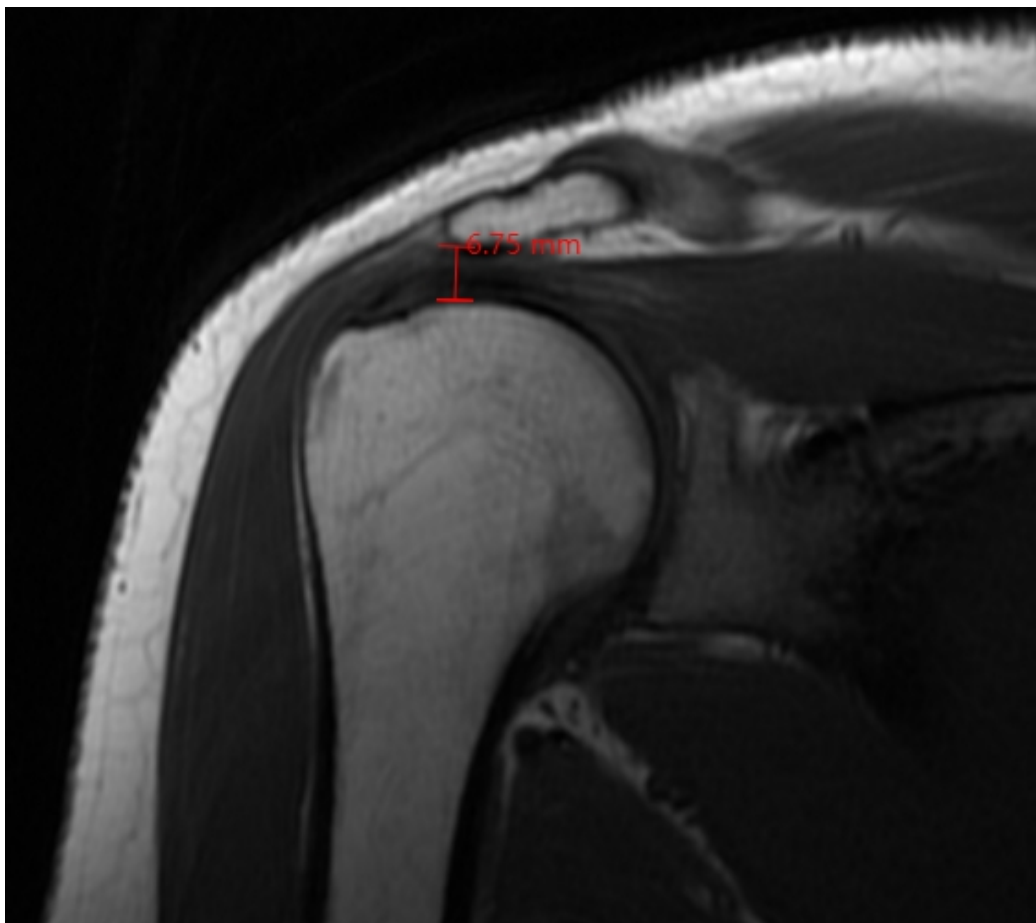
Measurement of acromio-humeral distance (AHD) on coronal oblique MRI.
